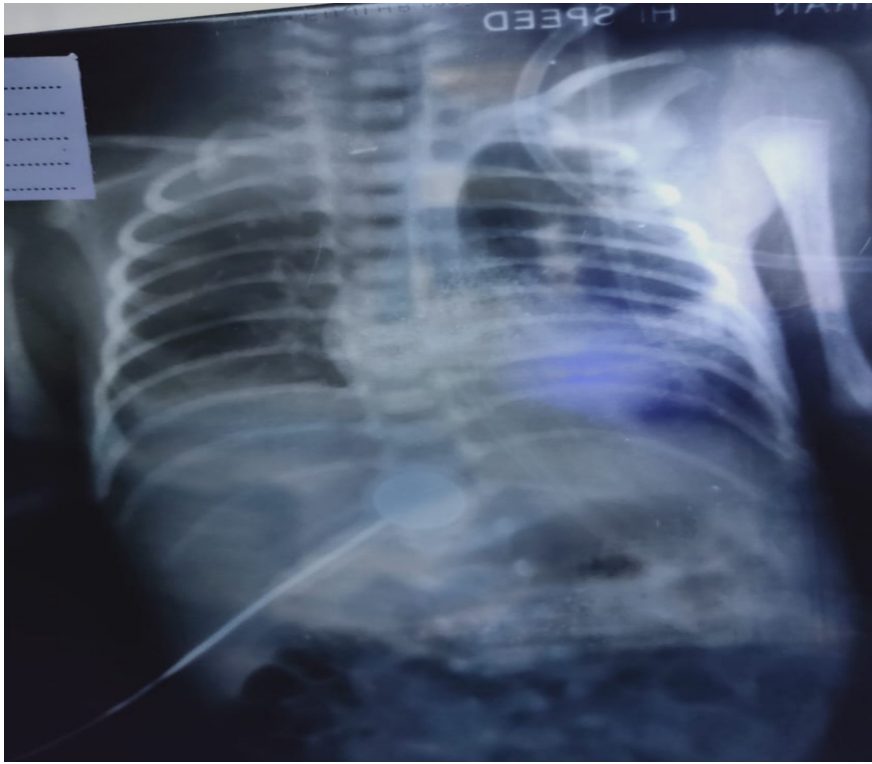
Chest X-ray showing pneumonia.
